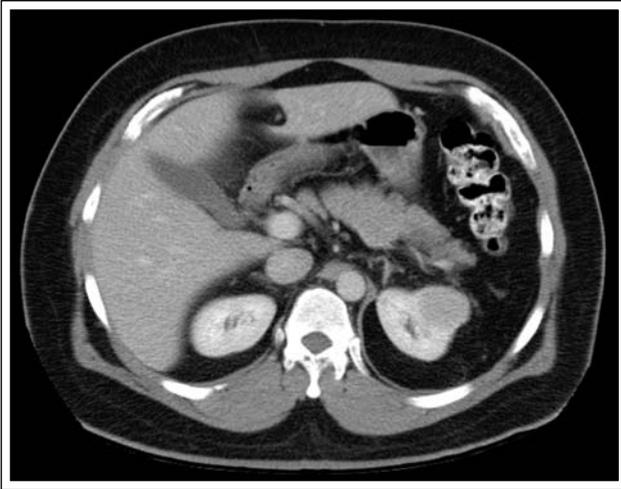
CT demonstrating exophytic solid mass, measuring 3.9 cm x 2.4 cm, arising from upper pole of left kidney.
